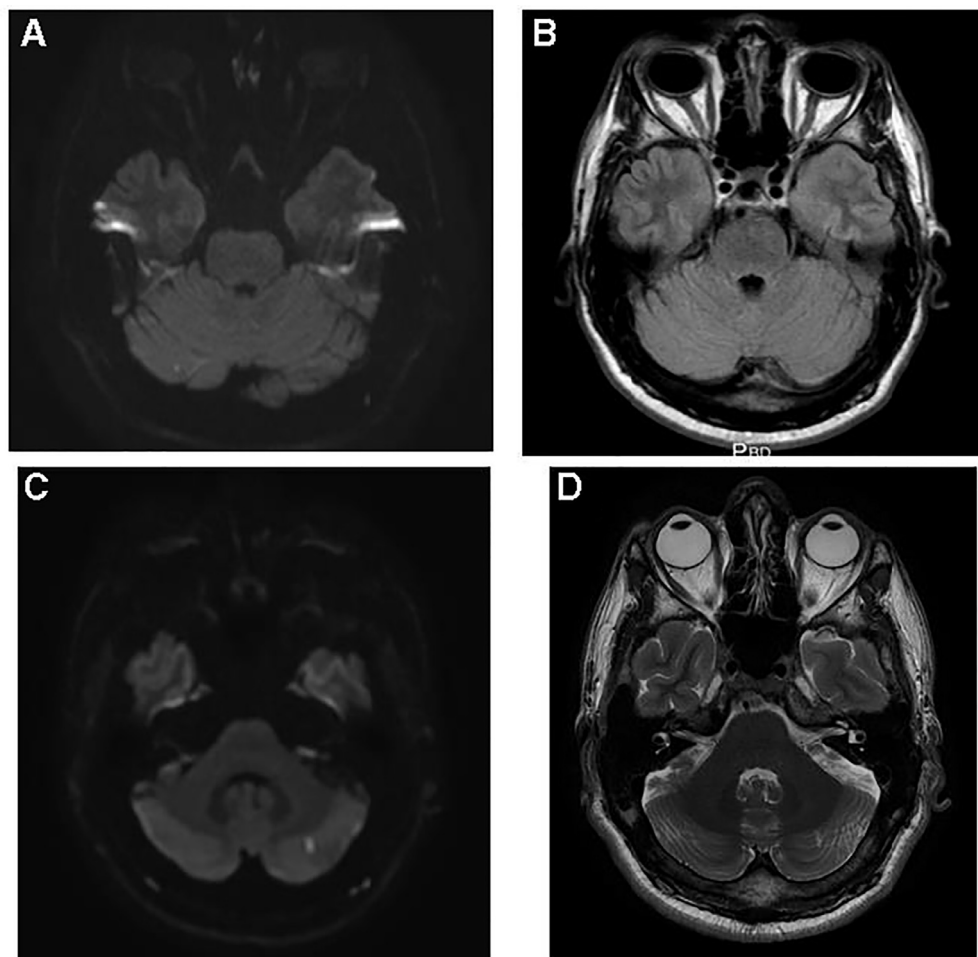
MRI images of patient 1. (A) Day 1 before alteplase; Diffusion sequence; (B) Day 1 before alteplase; Flair sequence. (C) Control; diffusion sequence; (D) Control; T2 sequence.
